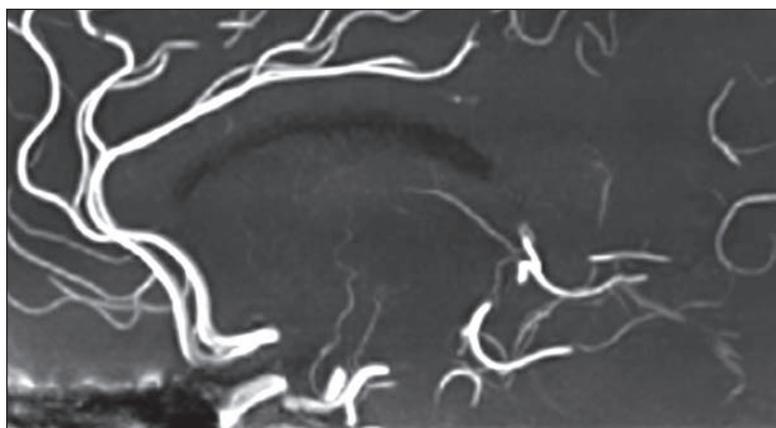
Time-of-flight angiography image of the posterior communicating artery with a perforating branch on 7 Tesla MRI, sagittal slab maximum intensity projection (thickness 7 mm)
